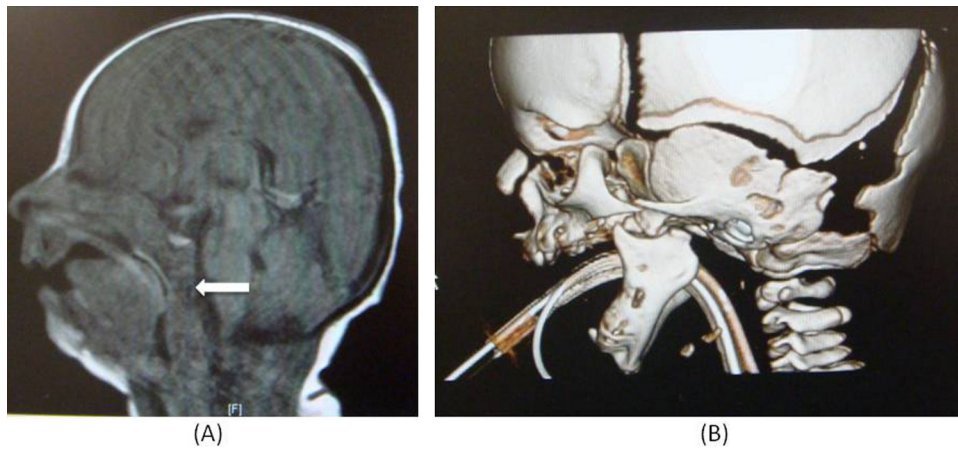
(A) MRI demonstrating significant retroglossal airspace obstruction (arrow). (B) CT of the craniofacial skeleton demonstrating a hypoplastic mandible, shortened vertical ramus, with a slightly flattened condylar head (Pruzansky IIB).
